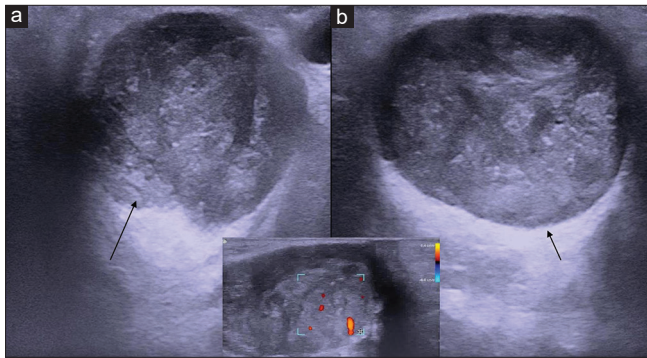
Perianal angioleiomyoma viewed with linear ultrasound probe in (a) Vertical (arrow), (b) Transverse sections (arrow) (presence of heterogeneous echotexture combined with posterior acoustic enhancement) and (c) Color Doppler examination of the lesion (vascular flow signal on color Doppler) (insert)
